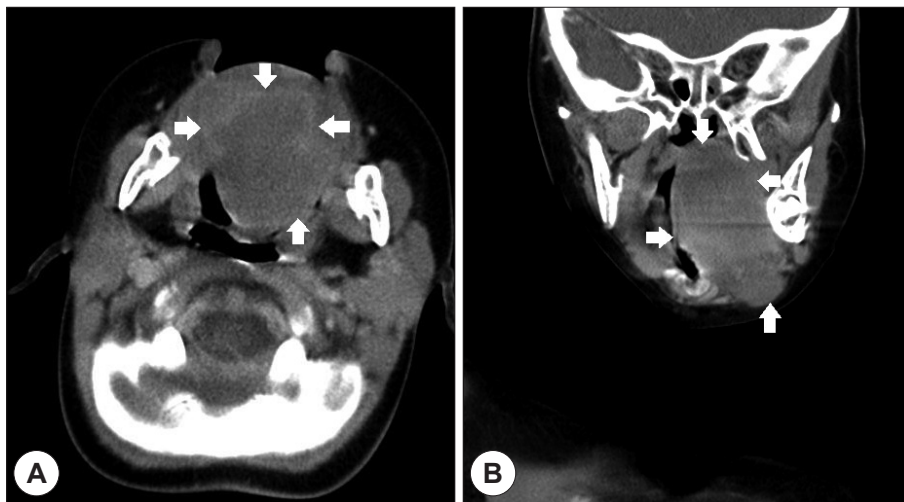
Enhanced CT images of the mass in axial(A) and coronal(B) cuts. A maximum 4.5 cm irregular heterogenous enhancing solid and cystic mass at tongue base with extension to Lt. sublingual space.
